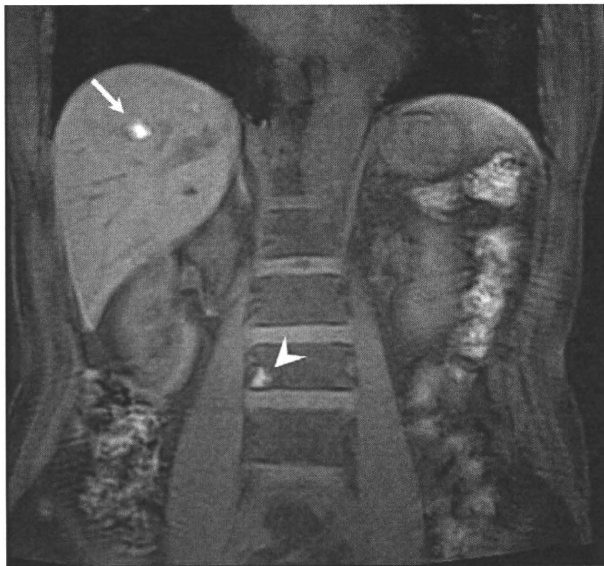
A 62-year-old man with malignant melanoma of uvea. The patient received radiotherapy for the right uveal melanoma. Contrast-enhanced CT showed intermediate lesion of the liver in segment 8. Fat suppressed coronal T1-weighted gradient-echo image obtained 2 years after radiation shows hepatic lesion with high signal intensity (arrow). Also noted is high signal intensity in the vertebra (arrowhead), which showed obviously growth on follow-up imaging and confirmed as spinal metastasis.
